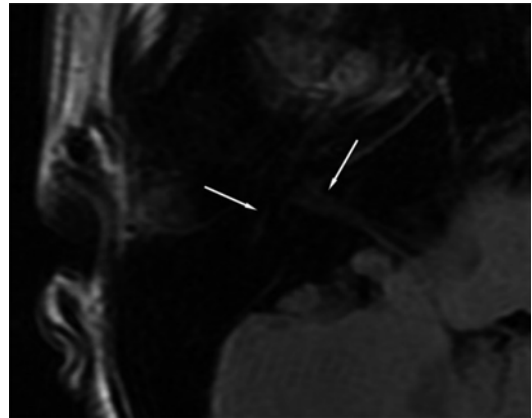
Pre-contrast axial T1 fluid-attenuated inversion-recovery axial image of the facial nerve (*arrows*) at the cerebellopontine angle (CP) angle, left arrow is pointing to the tympanic segment of the facial nerve and the right arrow is pointing to the labyrinthine segment of the facial nerve [Reprinted from H. S. Hong, B.-H. Yi, J.-G. Cha, S.-J. Park, D. H. Kim, H. K. Lee, and J.-D. Lee. Enhancement pattern of the normal facial nerve at 3.0 T temporal MRI. *Br. J. Radiol.* 2010; 83(986): 118–21. With permission from British Institute of Radiology.]
